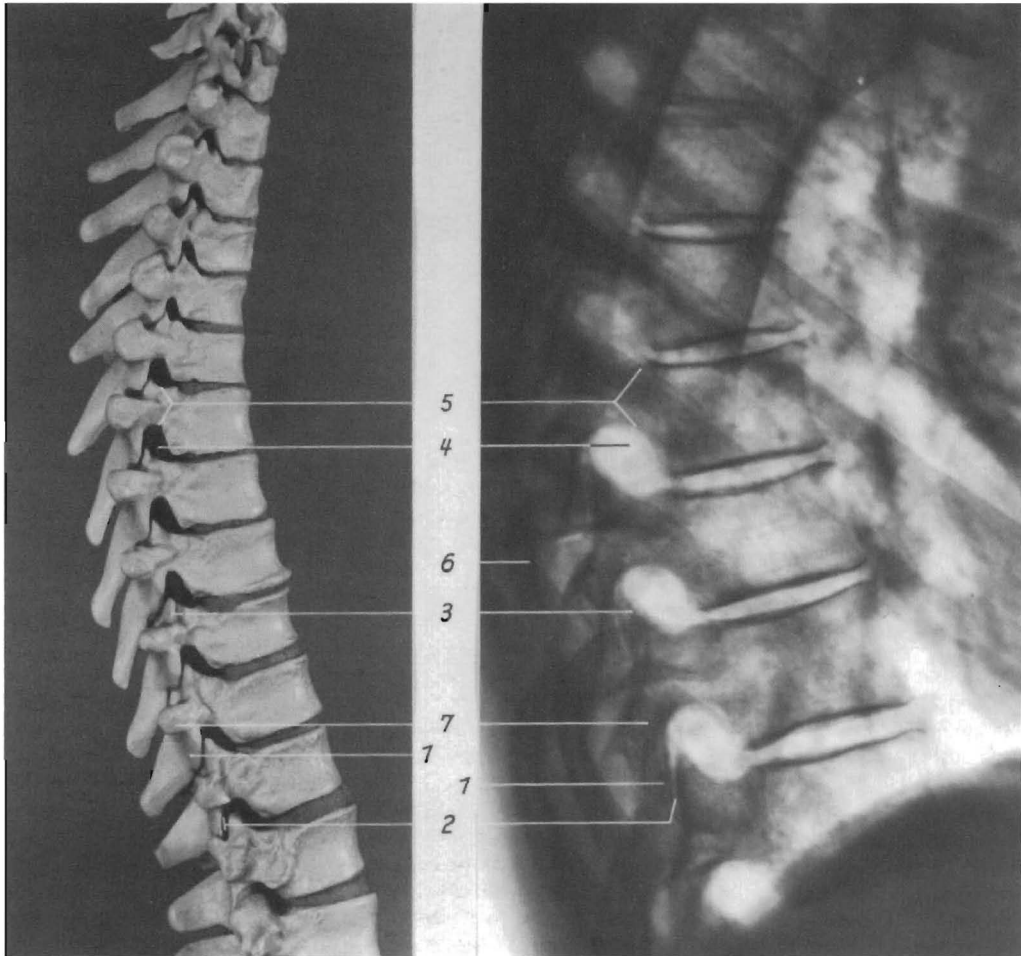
Comparison of the anatomical structures in the lateral view of the skeleton of the thoracic spine with the X-ray. 1, Lower articular process; 2, joint space; 3, upper articular process; 4, intervertebral foramen; 5, pedicles; 6, rib; 7, transverse process
